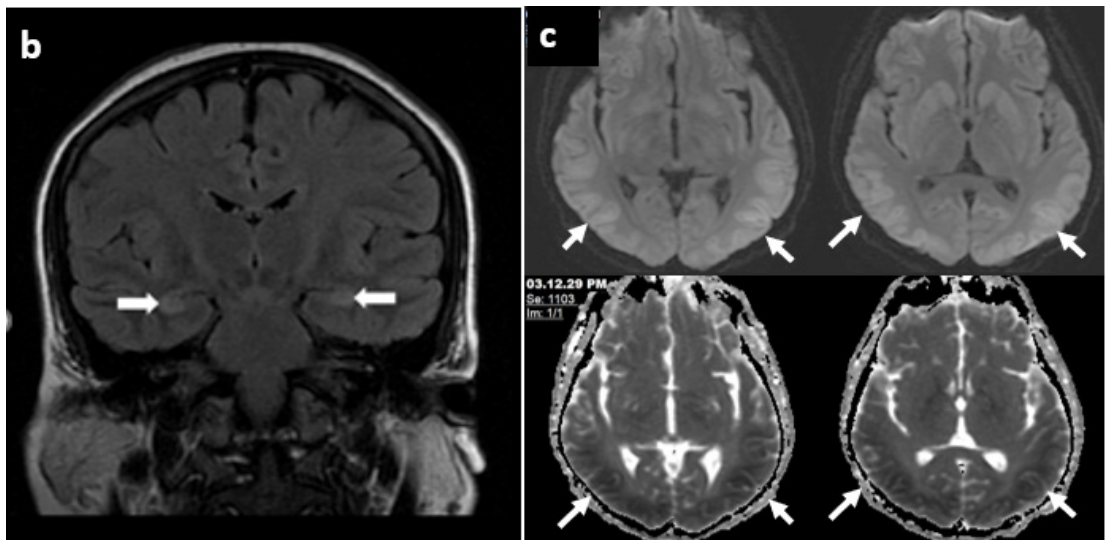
(b-c). A 25 years-old female with NMDARE encephalitis, the MRI image on figure 1b shows coronal FLAIR image which demonstrates symmetrical FLAIR hyperintense signal at bilateral hippocampus (white arrow). Figure 1c: 43-year-old male with NMDARE encephalitis, DWI (above) and ADC map (below) demonstrates areas of cortical restricted diffusion at both occipital and posterior temporal regions (white arrow).
